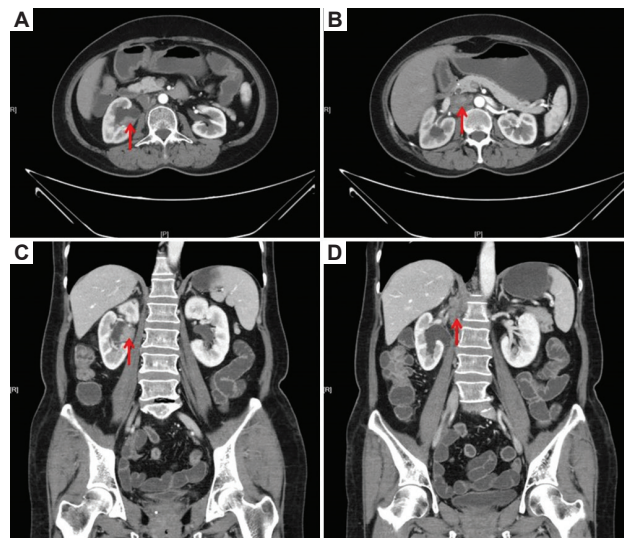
Contrast-enhanced computed tomography images of the patient's abdominal area upon admission. The images show a soft-tissue nodule (20 mm × 25 mm) in the right renal pelvis (indicated by red arrows in [A] and [B]), as well as a mass (40 mm × 25 mm) in the right retroperitoneal region and multiple enlarged lymph nodes in enterocoelia (indicated by red arrows in C and D).
